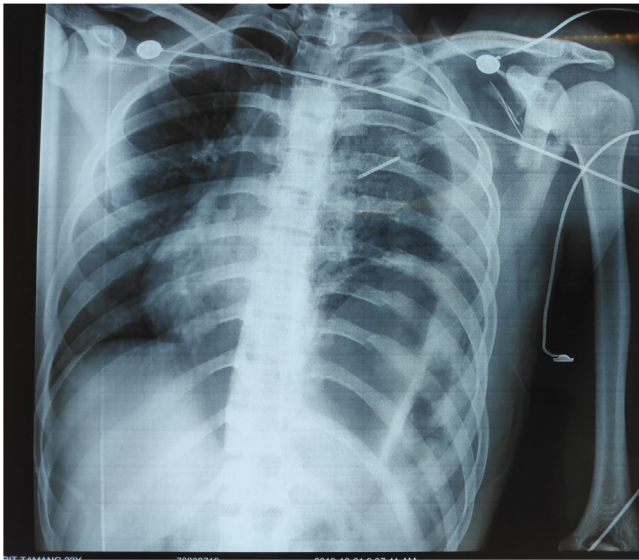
Chest Xray showing elevation of left hemidiaphragm and opacities in the left thorax with the needle used for decompression.
